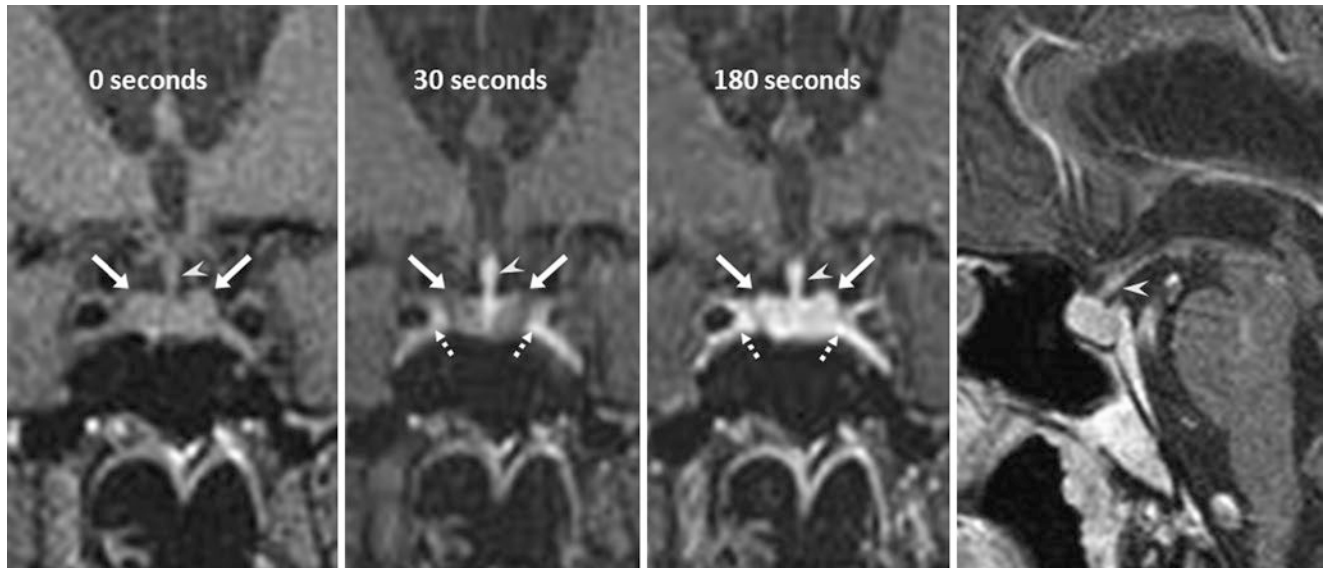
Normal lateral anterior lobe delayed enhancement. In a 67-year-old female with a negative 1.5 T MRI, the gland is homogeneously isointense prior to the use of contrast on coronal T1WI (left). The lateral, peripheral portions of the anterior lobes (arrows) are mildly hypointense at
